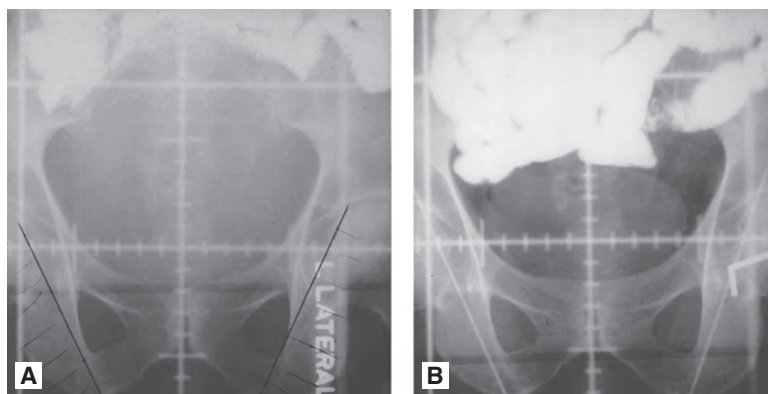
A,B: Anterior–posterior radiographs with and without bladder distention in a patient with contrast in small intestine.
